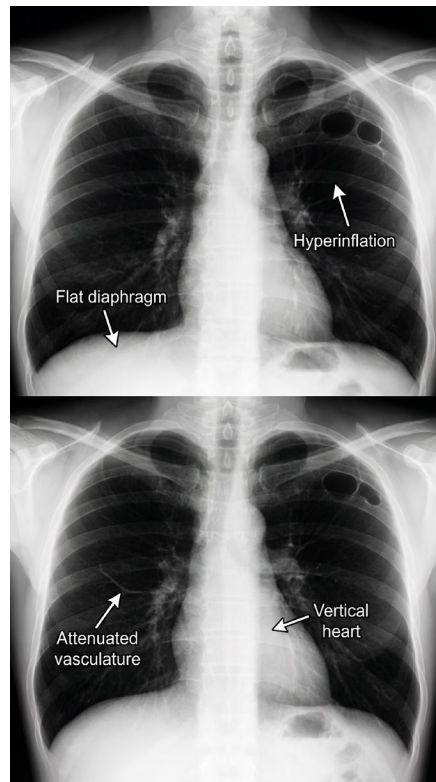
Chest X-ray (PA view) demonstrating emphysematous changes. Annotated findings include bilateral hyperinflation, increased retrosternal airspace, hyperlucency, flattened diaphragms, attenuated vascular markings, and a vertical cardiac silhouette.
